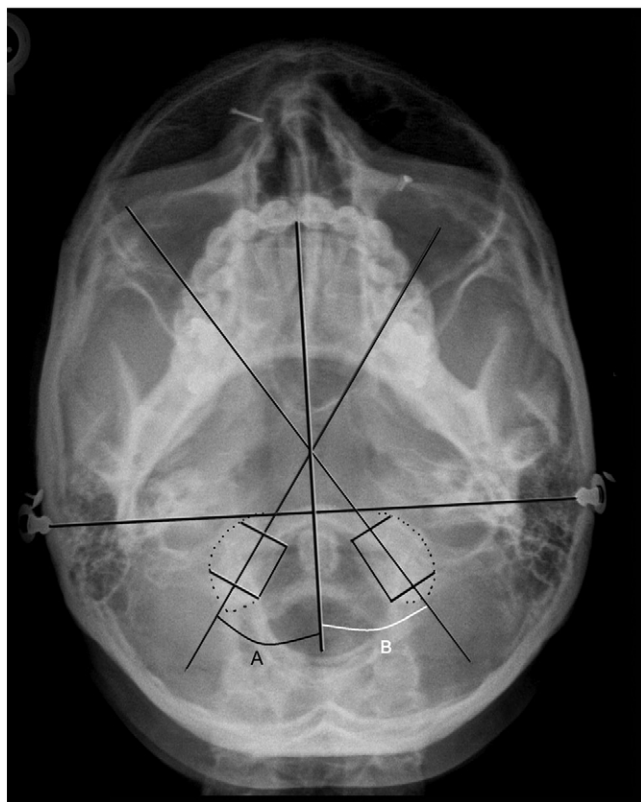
A base posterior radiograph. Leaded ear plugs are placed in the patient's external auditory meatus allowing for the creation of an earplug line. A sagittal line is then drawn perpendicular to the earplug line, allowing a reference to the occipital condyle angle. The left and right OA articulation is outlined, and the convergence angle of each articulation is drawn down the long axis of the joint. A, The right convergence angle. B, The left convergence angle.
